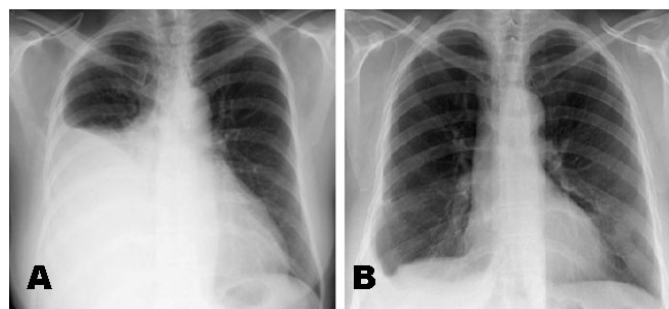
AP chest X-ray of a patient with rheumatoid arthritis showing large right-sided pleural effusion at presentation (A) and one month after treatment with Prednisone and Rituximab (B).
